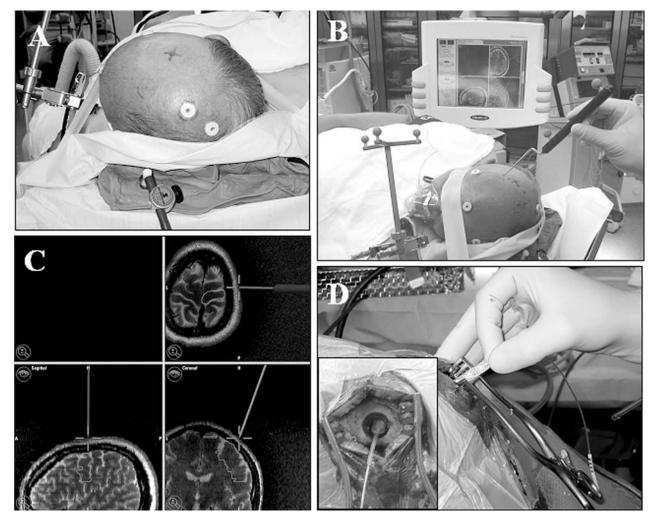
(A) Photographs showing the patient's position; the head is turned approximately  $80^{\circ}$  to the left side and is securely affixed in a vacuum head rest. (B) The central sulcus is localized using image guided neuronavigation. (C) Triplanar MRI scans; the navigation monitor displays gray crosses, which represent the target area. The straight line shows the preplanned vector and the possible site for single burr-hole. (D) Intraoperative image showing the cranial burr-hole and the placement of monitoring electrode
